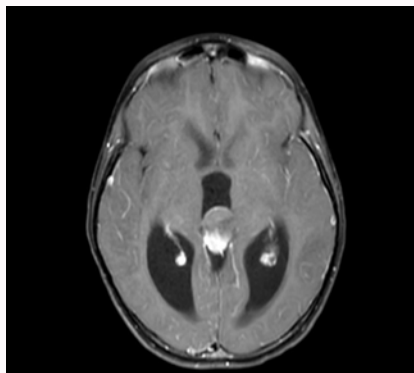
Axial T1-weighted image with gadolinium injection showing a pineal lesion that is heterogeneously enhancing.
